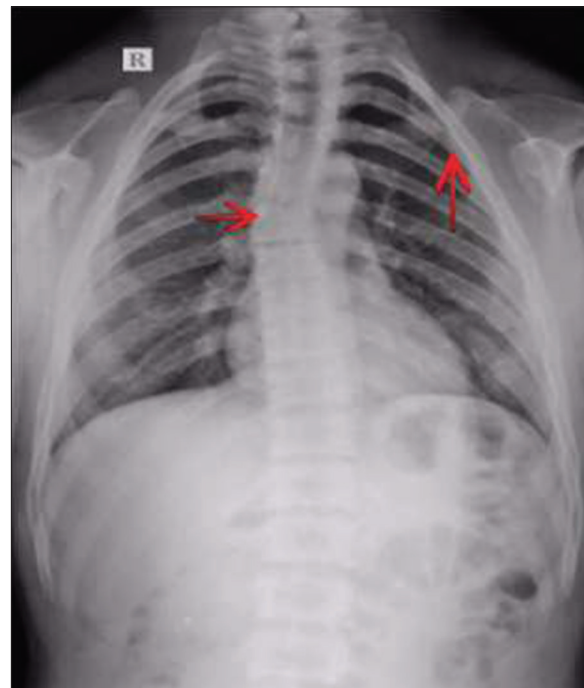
Chest X-ray posterioranterior view: Hypoplastic bilateral clavicles, narrow thorax with scoliosis of thoracic spine toward right side (arrows)
